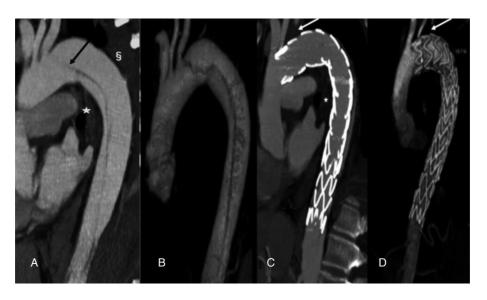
A-B: MultiDetector Computed Tomography (MDCT) images of acute type B dissection: the entry tear is close to the origin of left sub-clavian artery (black arrow); active mediastinal hematoma (*) and pleural effusion (§) are also visible. C-D: MDTC MIP (C) and VR (D) images demonstrating complete obliteration of the false lumen with endovascular stent graft positioned immediately after the origin of left common carotid artery with occlusion of the proximal segment of the left sub-clavian artery (white arrow); mediastinal hematoma (*) and pleural effusion are resolved.
